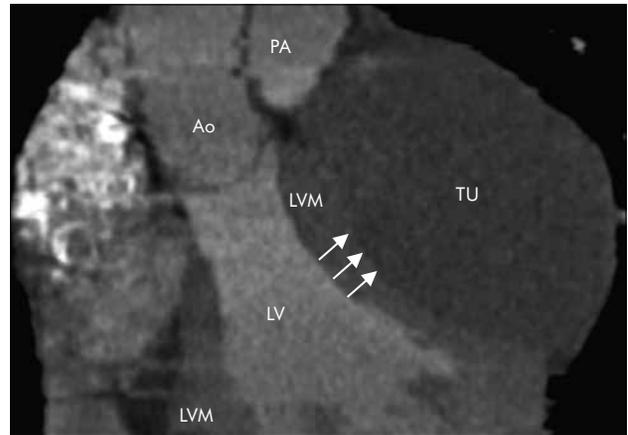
Computed tomography. Chest scan. Left contour of the heart irregularly enlarged (arrows)
